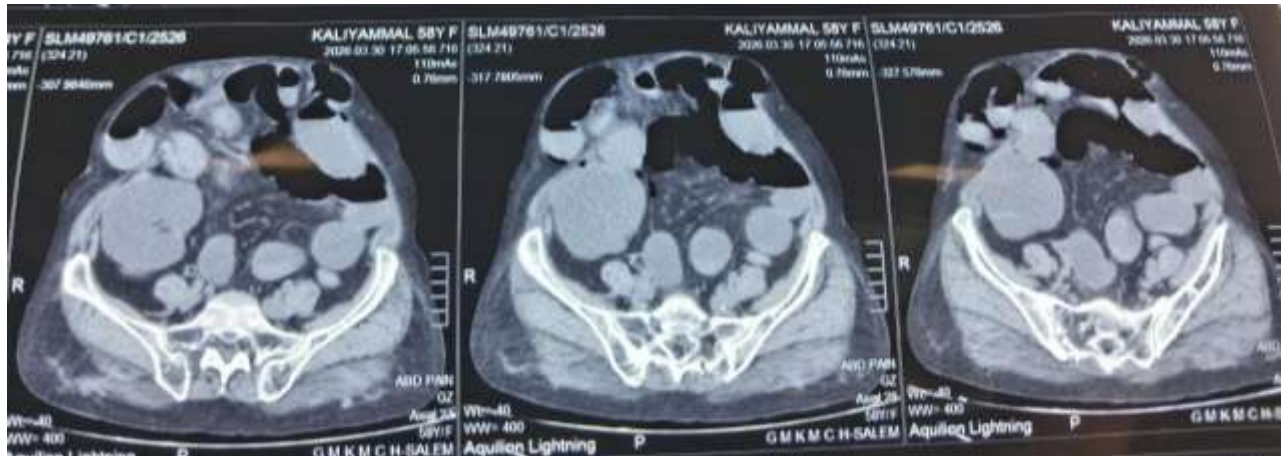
CT ABDOMEN showing incisional and right spigelian hernia with bowel and omentum as contents
